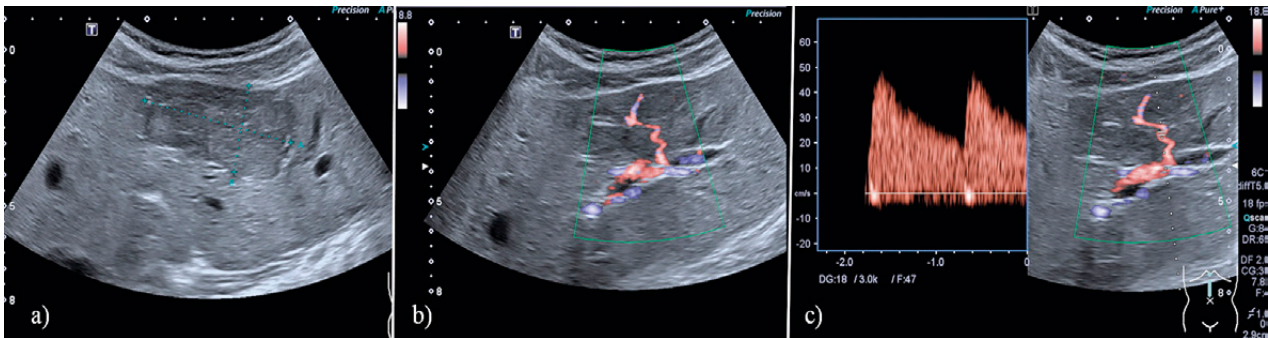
Flow signal of a feeding artery. B-mode ultrasound (a), color Doppler ultrasound (b) and spectral Doppler ultrasound showing a central feeding artery in FNH with low resistance profile (c) [6,124,125].
